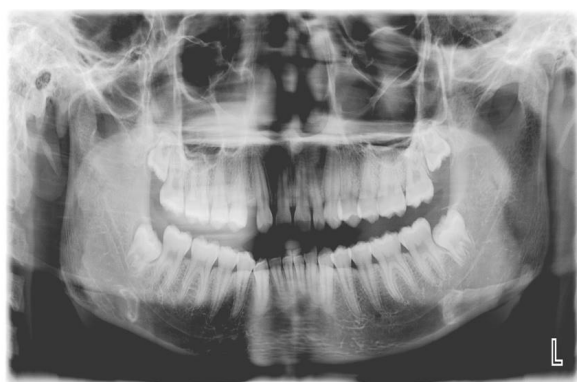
Panoramic radiograph shows hypodontia of maxillary right lateral incisor, microdontia of maxillary left lateral incisor and taurodontism of maxillary and mandibular second molars
